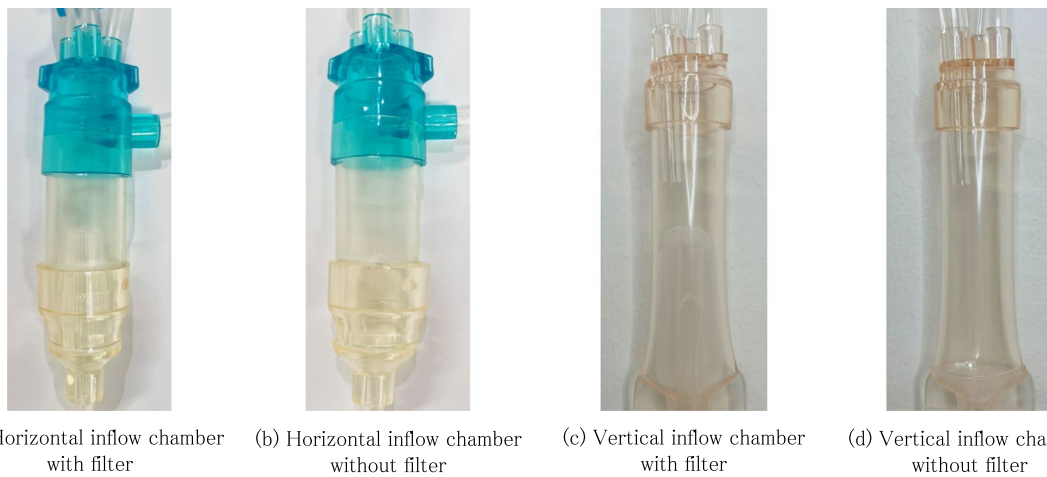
The venous air trap chambers used in the in vitro experiments. The blood circuits used in the in vitro experiments consisted of a horizontal inflow chamber: the SUREFLOW N circuit, and a vertical inflow chamber: the CHDF-FSA circuit, both featuring integrated filters. Initially, the chambers were modified by cutting the bottom of the chamber using an ultrasonic cutter, followed by removing or not removing the filter and a rejoining of the chamber parts. The chamber volumes were adjusted to 15 ml
